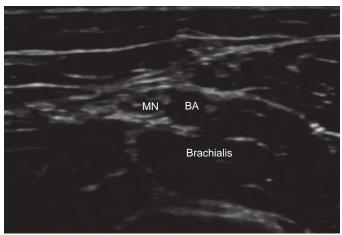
Ultrasound image of median nerve (MN) at the level of the elbow.
